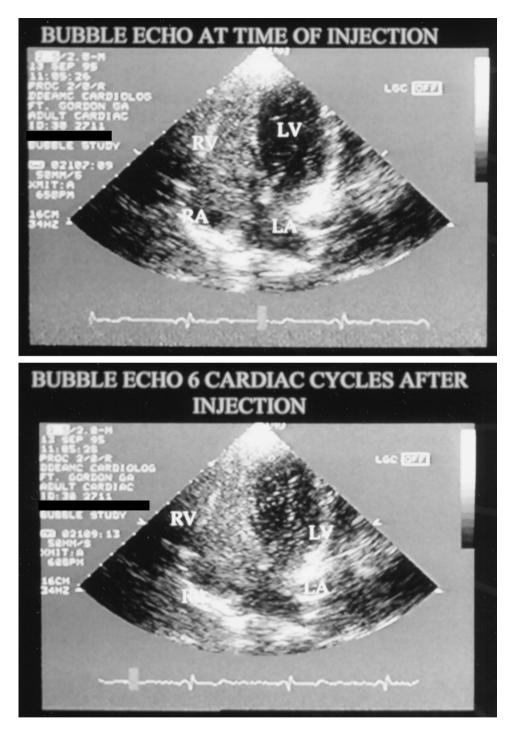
Bubble contrast echocardiogram showed delayed microbubble opacification of the left ventricle consistent with intrapulmonary vasodilatation.
